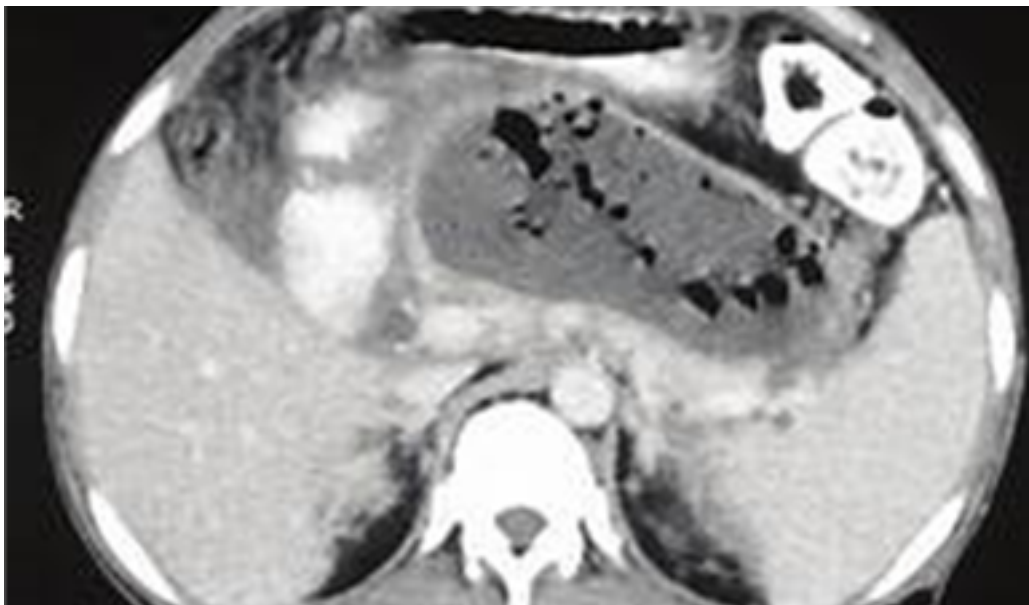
CT image of WOPN.
